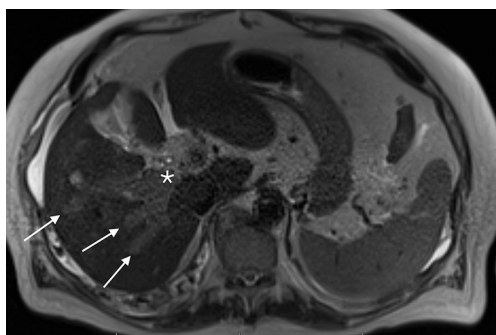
A 72-year-old man with cryptogenic cirrhosis found to have large right lobe of liver HCC with extensive portal vein invasion. Tumor thrombus extends into branches of the right portal vein (white arrows) as well as the main portal vein (white asterisk). This T2 weighted MRI shows relative hyperintensity of the portal veins. Normal patent portal vein would show hypointensity secondary to flow void. He underwent treatment with Y-90 embolization.
